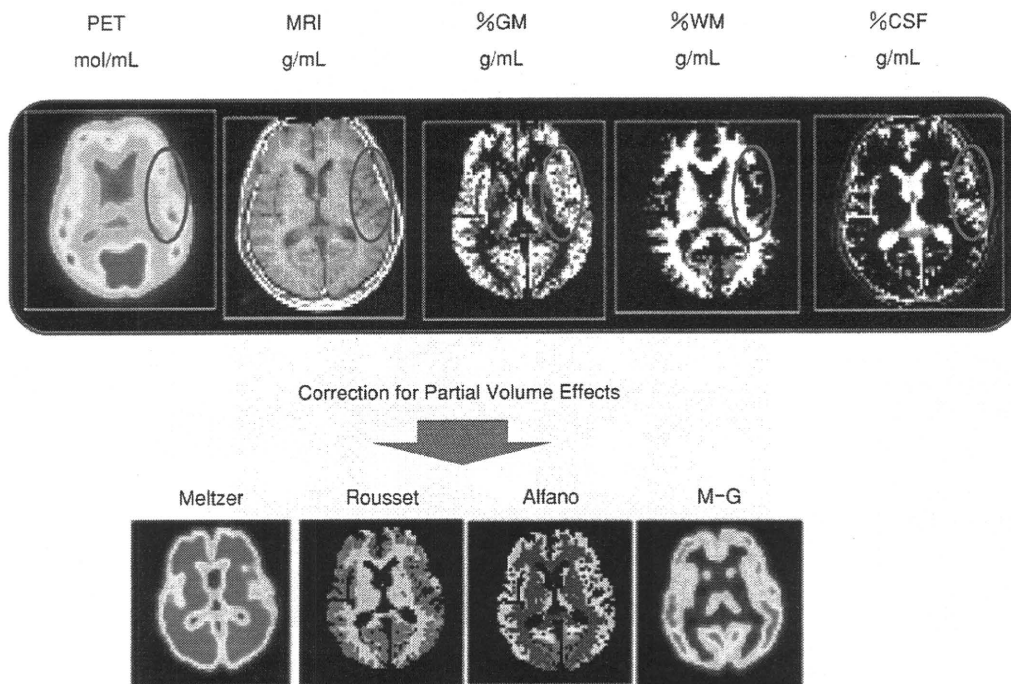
MRI 形態画像の部分容積効果の補正への利用
